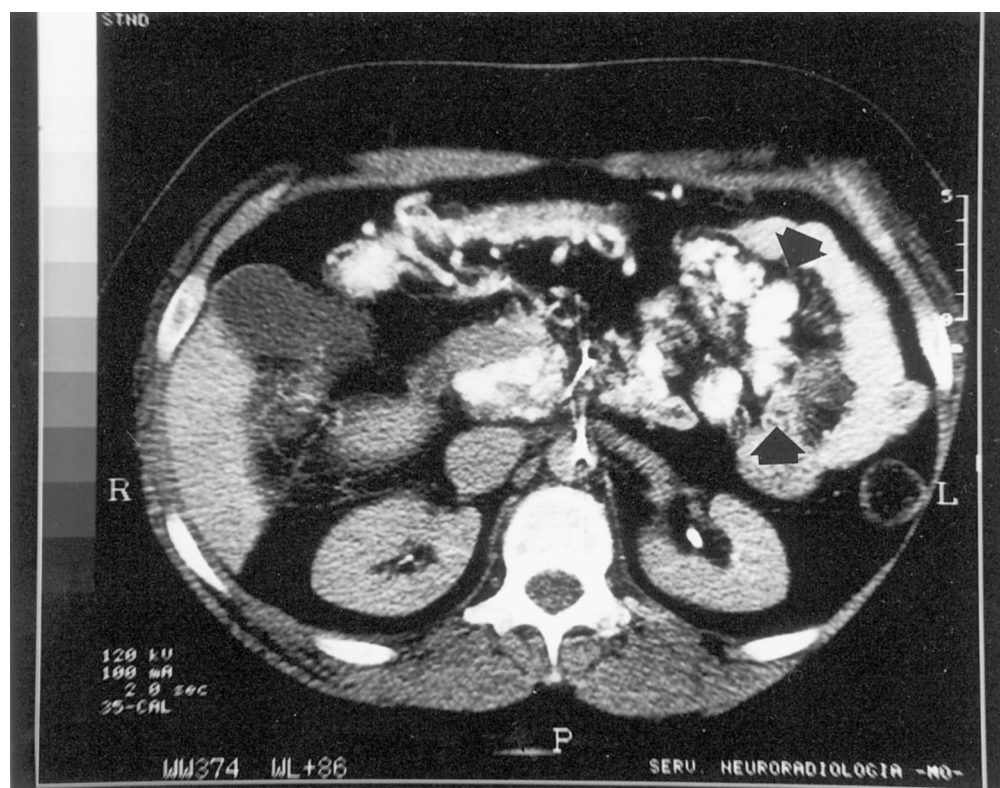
CT portography showing large jejunal varices (arrows).
